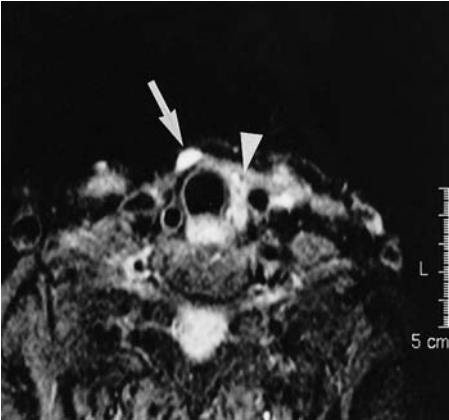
Follow-up of a differentiated thyroid cancer with clear, unsuspecting thyroid remnants. Two years after a sella metastasis was treated by external beam radiation, a palpable mass occurred in the pretracheal region, which was also shown by sonography. In contrast, ^{99m}Tc -sestamibi showed two lesions. MRI demonstrated one larger lesion in the pretracheal midline corresponding to the sonographic finding (not shown) and a smaller one caudally. The STIR image shows the smaller finding (*arrow*) at the same level of some contralateral thyroid remnant (*arrowhead*)
